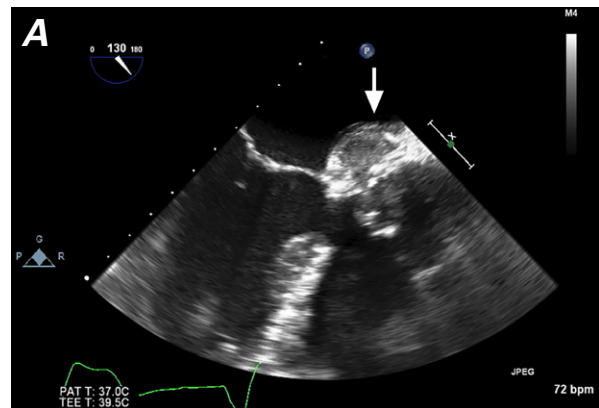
One month postprocedurally, transesophageal echocardiograms in A) standard and B) color-flow Doppler modes show normal bioprosthetic valve function. The thrombosed pseudoaneurysm (arrow) is visible in the fibrous trigone.
